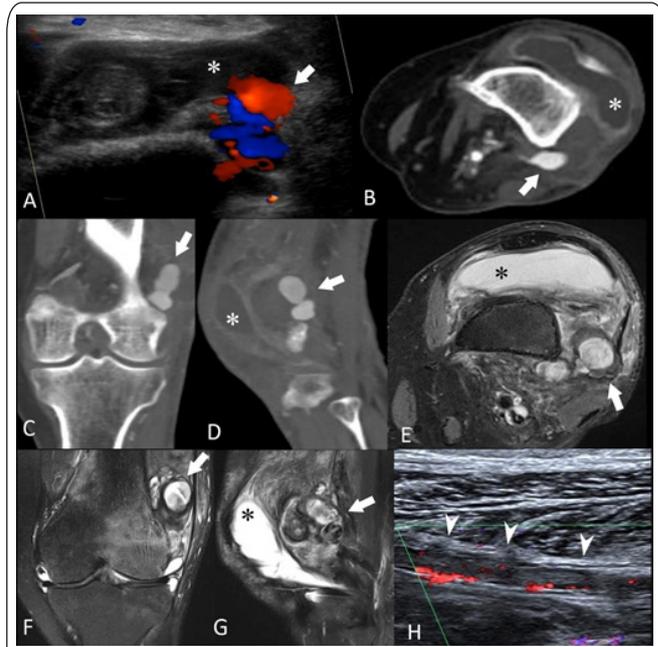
Targeted ultrasound of the left knee demonstrates a pseudoaneurysm (arrows) which measures 63 x 31 x 44 mm, with a neck of 1 x 2 mm (width x length) arising from a lateral geniculate arterial branch (Image A). The pseudoaneurysm sac is largely thrombosed with minimal flow seen within. The popliteal artery is patent and three-vessel run off into the calf is noted. CT angiogram of the left knee delineated the anatomy, confirmed the presence of an actively bleeding lateral genicular artery pseudoaneurysm, a large traumatic knee joint effusion (asterisks), and excluded an arterio-venous fistula [Images B (axial), C (coronal), and D (sagittal)]. The patient declined to have a thrombin injection at this juncture. A left knee MRI was subsequently performed due to concerns for collateral ligament injury, although no ligamentous defects or meniscal injuries were identified [Images E (axial), F (coronal), and G (sagittal)]. The patient eventually agreed to undergo UGTI the following day. Approximately 1500 IU thrombin was slowly and carefully injected into the pseudoaneurysm until clotting ensued and thrombosis achieved. Post-procedure, real-time ultrasound demonstrates propagation of arterial thrombus into the left popliteal artery and calf arteries, extending caudally until the ankle level [Image H – (arrow heads)]. The patient was asymptomatic and the foot remained warm post-procedure. An urgent left popliteal arterial thrombectomy, and vein patch angioplasty was performed, removing a large volume of thrombus from the popliteal artery, tibial-peroneal trunk, and all three run-off vessels in the calf. Patient recovered well post-procedure.
